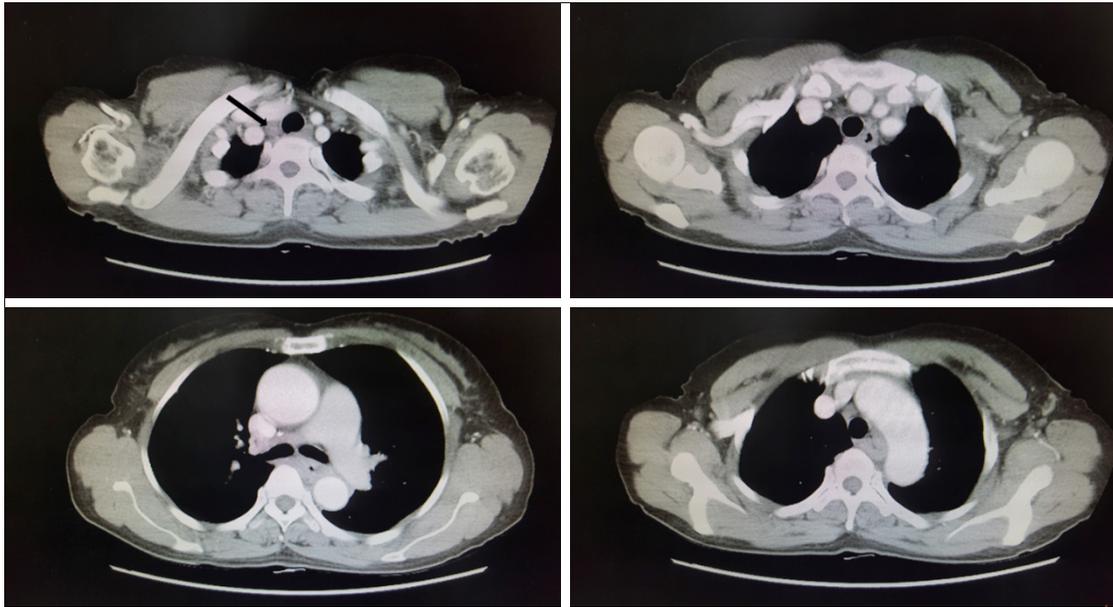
Enhanced CT scan. The black arrow indicates an enlarged lymph node beside the right recurrent laryngeal nerve.
